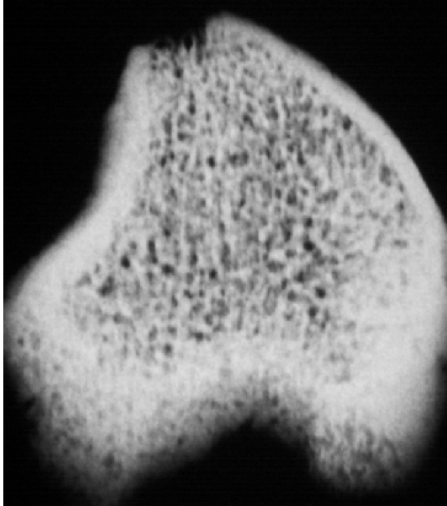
Contact X-ray of a RPC sample proximal side up.
